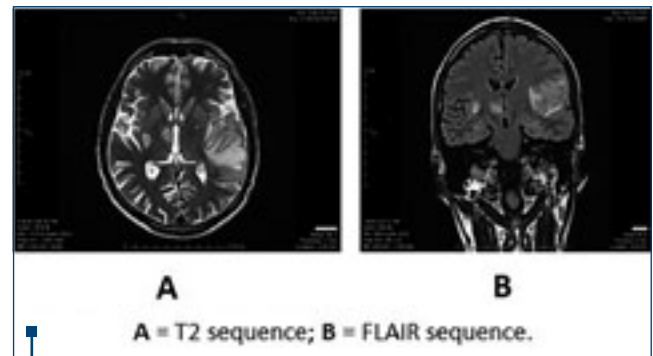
MRI revealing hyperintense T2 and FLAIR left subcortical temporal and frontoparietal inhomogeneous areas, with adjacent pachymeningitis, and infracentrimetric abscess in the right lentiform nucleus
